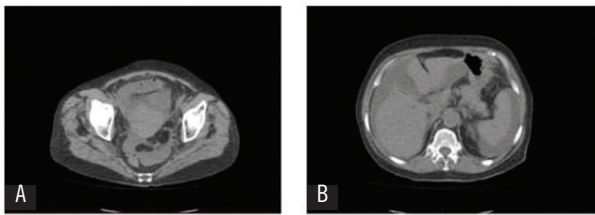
Transverse plane of CT scan
